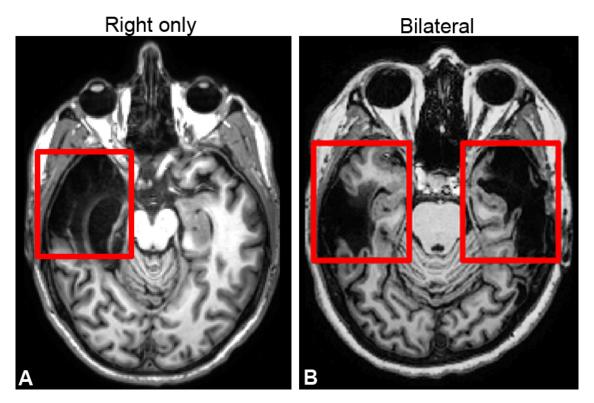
Axial images from magnetic resonance imaging of two patients with 'associative' prosopagnosia. A) Unilateral anterior temporal damage in a 40 year-old man (R-AT3) presenting with prosopagnosia. B) Bilateral anterior temporal damage in a 47 year-old woman (B-AT2) presenting with prosopagnosia.
